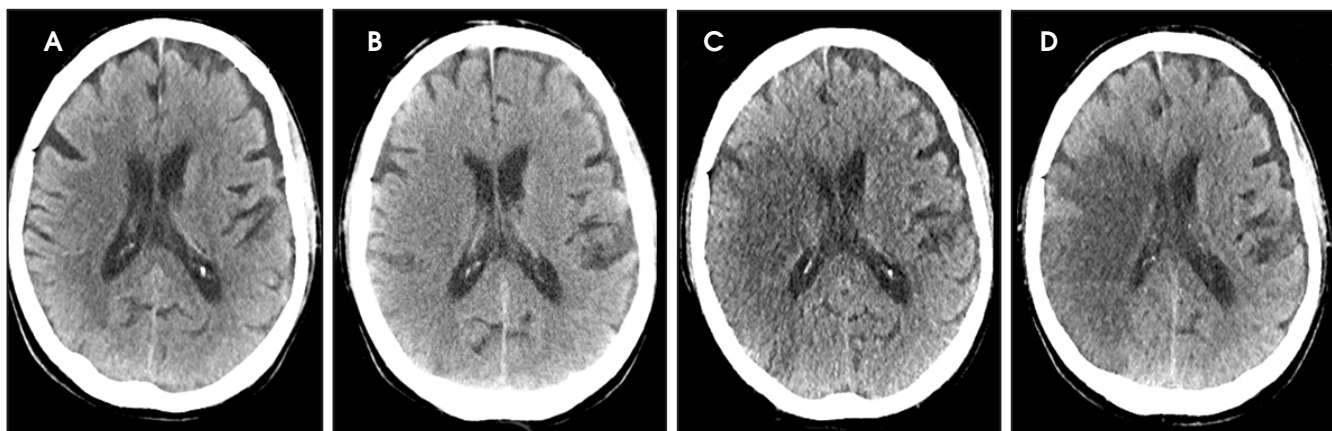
Evolving right MCA infarction. (A) Initial NCCT scan with a routine SAFIRE low-dose CT protocol. (B) Follow-up CT performed at standard dose 8 hours later. Note the subtle obscuration of the gray-white matter interface and poor definition of the caudate. Follow-up (C) ultra-low dose SAFIRE exams 28 hours and (D) 40 hours after the initial exam (A).
